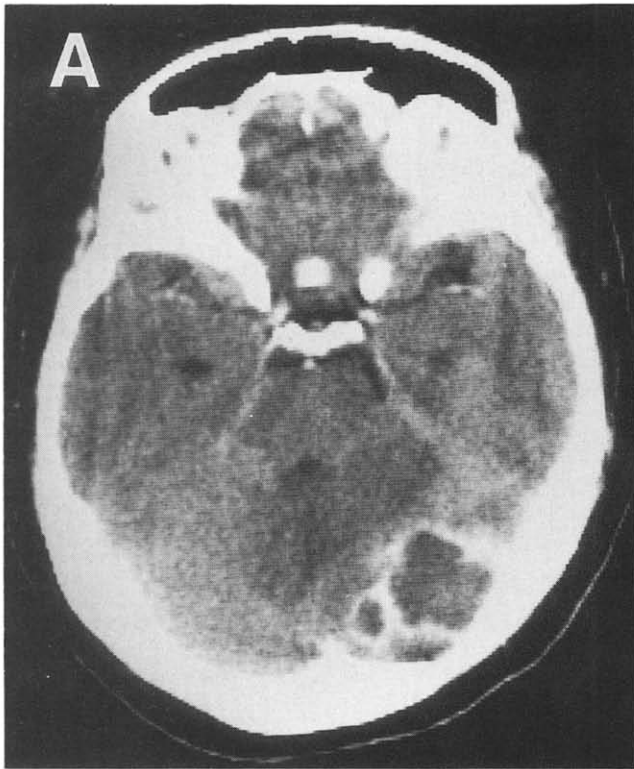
Case 3. (A) Contrast-enhanced CT scan. (B) T₁-weighted image. (C) T₁-weighted gadolinium-DTPA-enhanced image. (D) T₂-weighted image of MRI.
